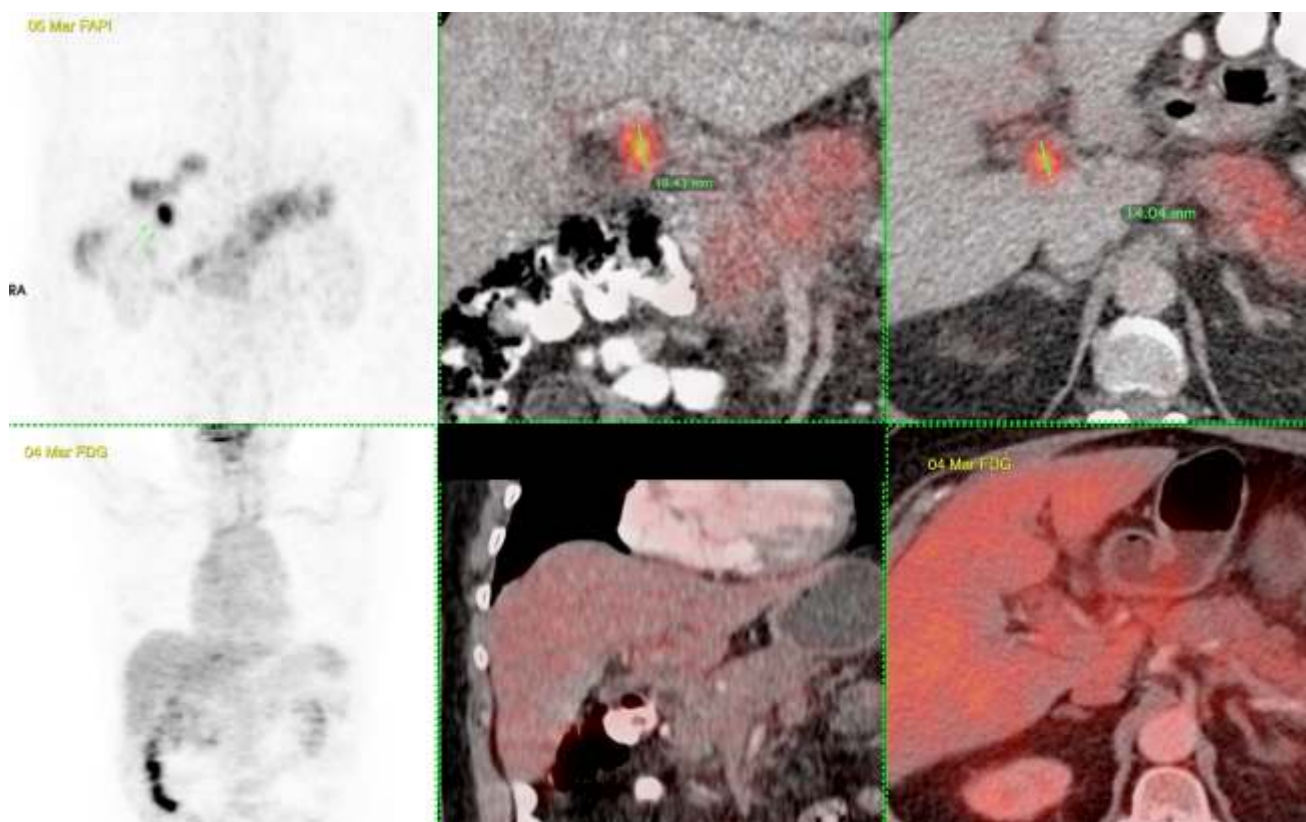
70-yr old man with cholangiocarcinoma. Post-chemotherapy, a staging FDG PET/CT (lower panel) showed no tumor or uptake. A FAPI PET/CT the next day (upper panel) clearly showed the cholangiocarcinoma with FAPI uptake, measuring 14 mm in transverse diameter and 18.4 mm in supero-inferior extent. Cholangiocarcinoma usually has low FDG avidity and in this situation, it showed only FAPI uptake and no FDG uptake, allowing us to accurately stage it on FAPI PET/CT.
